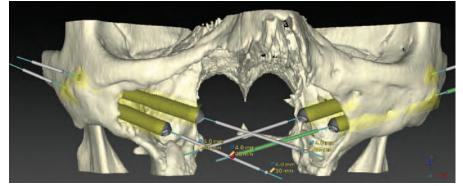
Virtual implant planning was carried out using the CT scan data to estimate the implant positions and lengths.
